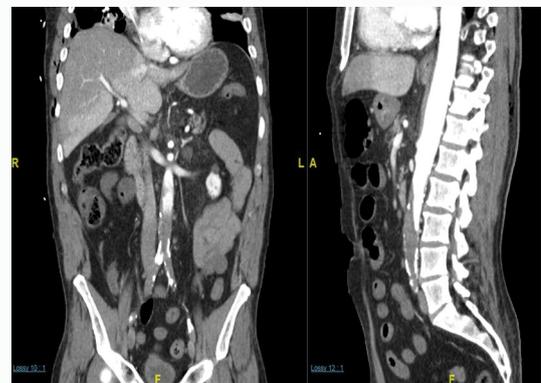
Coronal (left panel) and sagittal (right panel) images from Computerized Tomography (CT) angiogram, which was taken after an episode of malignant hypertension, with systolic blood pressures of 230 mmHg - 240 mmHg, and loss of pedal pulses and which reveals abdominal aortobiliac thrombotic occlusion, proximal superior mesenteric artery dissection with distal occlusion, and renal and splenic infarction.
